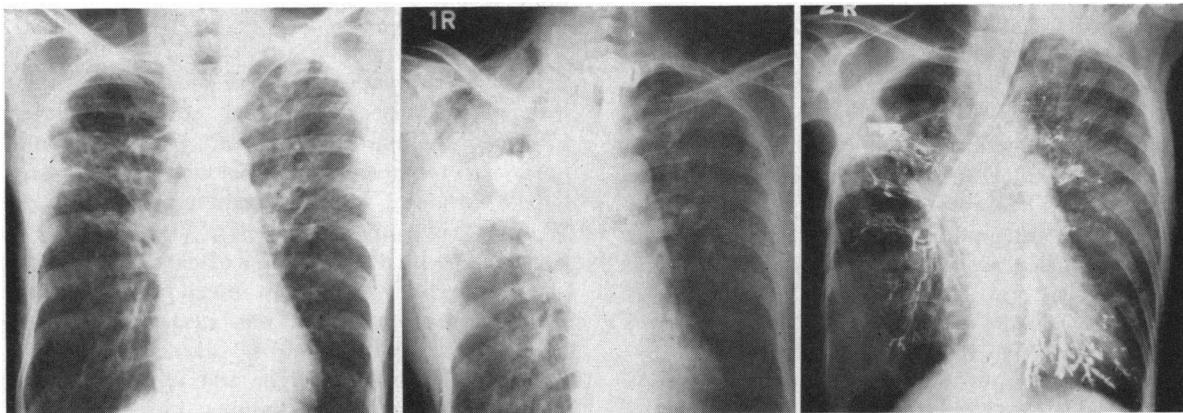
(Case 6). *Left*, roentgenogram after 11 months of antituberculosis chemotherapy, showing large right apical cavity. *Center*, roentgenogram taken two days after division of the right upper lobe bronchus and three-rib thoracoplasty, showing cavity definitely smaller. A contrast medium had been instilled into the cavity at operation. *Right*, bronchogram taken two months postoperatively, showing cavity much larger and recanalization of the bronchus.
